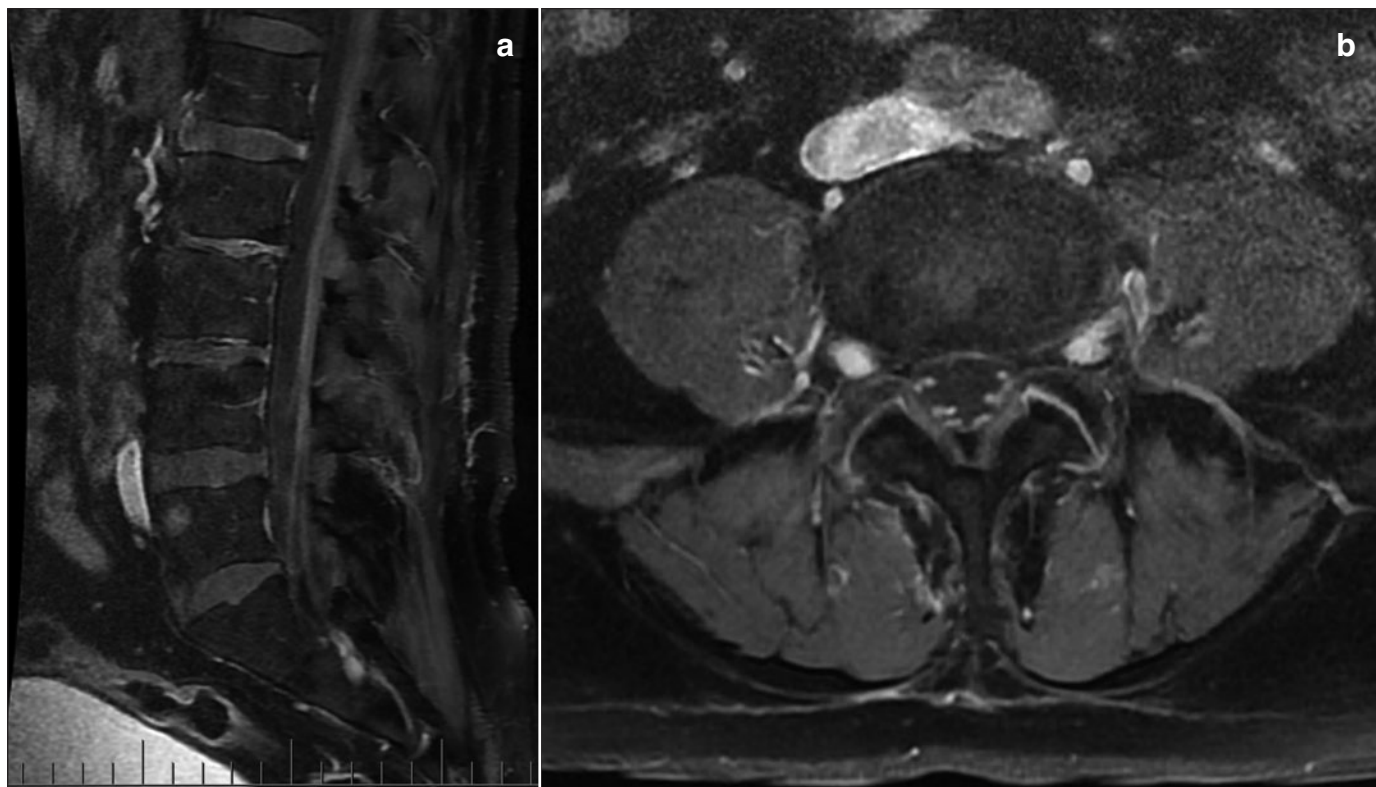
(a) Sagittal and (b) axial T1-weighted MRI with gadolinium demonstrating pathological nerve root enhancement as well as vertebral metastases.
